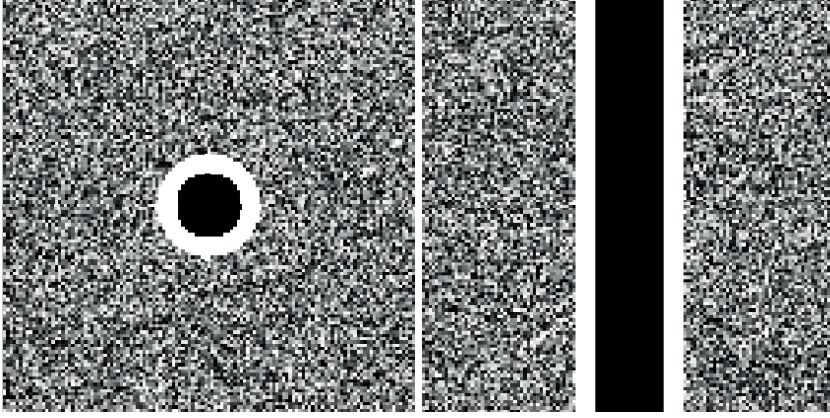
Optimal ultrasound vessel model. The lumen consists of a dark region which is surrounded by a bright border ring with a given thickness. The region outside the border ring is modeled by noise.
